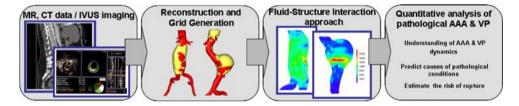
The "patient specific diagnostics" approach is composed of four major steps. Collection of medical data using novel imaging modalities such as computed tomography (CT), magnetic resonance (MR), and intravascular ultrasound (IVUS) imaging. Accurate delineation of the pathological structures of interest and introduction of these three-dimensional patient specific structures to grid
